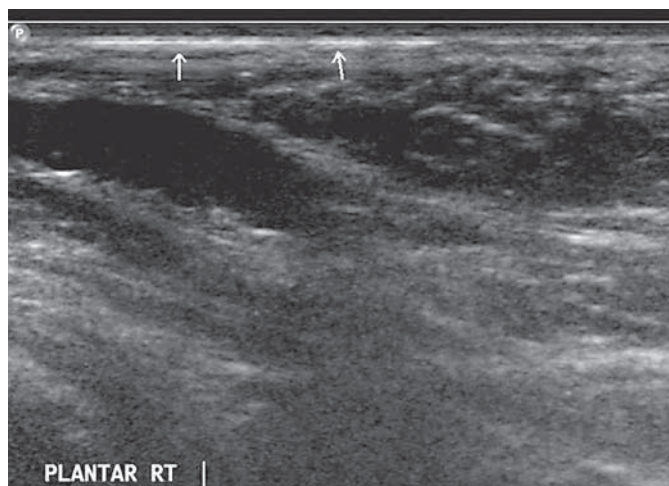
Ultrasound examination in MDM patients demonstrates a hyperechogenic thickened keratin layer at the epidermis (arrows) but no blisters between the epidermis and the dermis.
